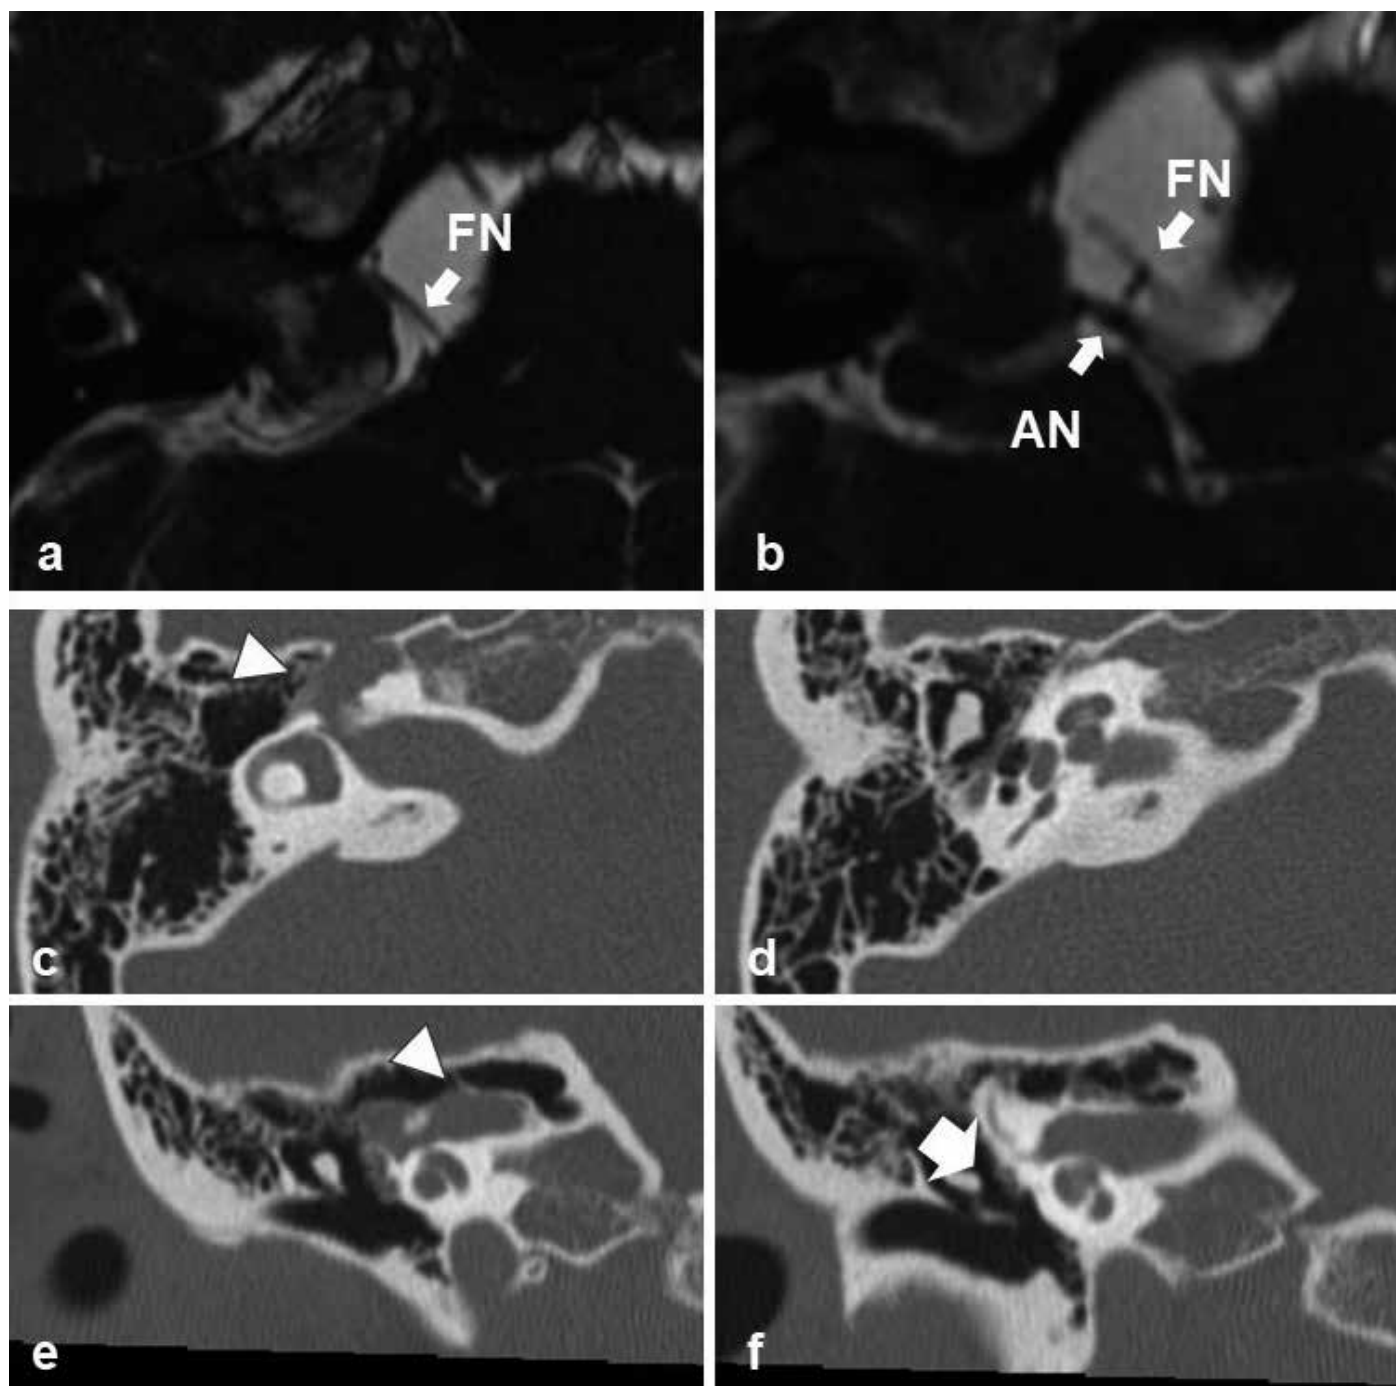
a-f. Preoperative imaging findings. Preoperative MRI revealed that the cisternal portion of the facial nerve (FN) remained intact and was not involved in tumor, while the auditory nerve (AN) was completely encompassed (a, b). Preoperative CT revealed that the bone surrounding the geniculate ganglion was disrupted by the tumor (arrowhead) (c, e). The bone surrounding the cochlea was undamaged (d), and the vertical portion of the facial nerve was not involved in tumor (f).
